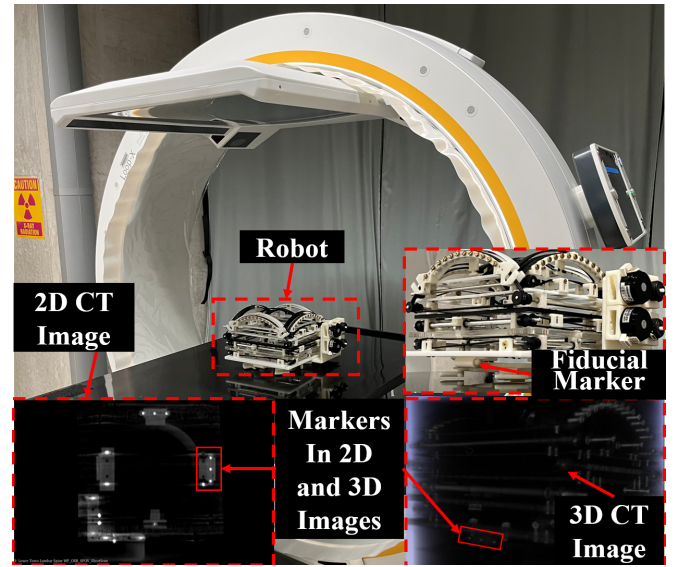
Epidural Steroid Injection robots with fiducial frame in CT images. 2D CT images with fiducial markers(Left). Real robot with fiducial frame in CT scanning and 3D CT images of the fiducial markers(Right).
